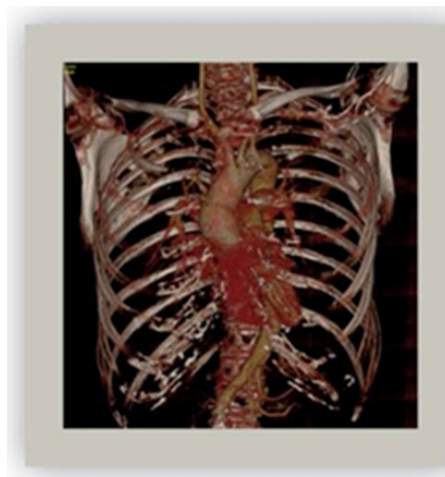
Thorax CT 3d volume rendering.
